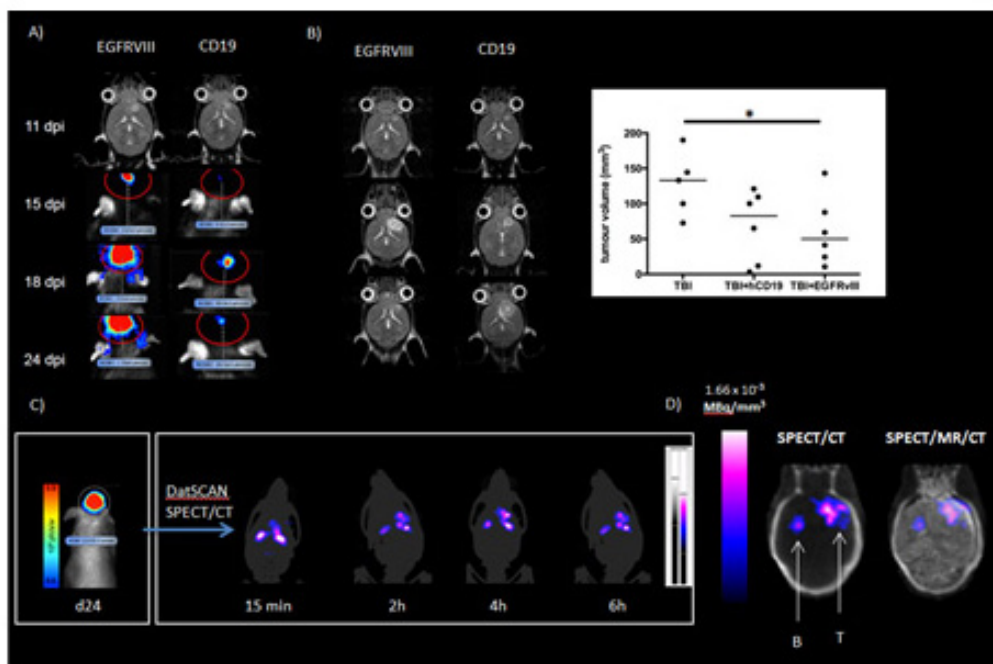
A) MRI of GL261 tumours pre-treatment at day 11, and BLI of subsequent CAR T cell uptake (EGFRvIII or Control CD19) at days 15, 18, and 24. B) MRI of GL261 tumour size pre-treated (top row) and post treated (EGFRvIII or Control CD19), and a graph of tumour volumes. C) BLI indicating hDAT (+) SupT1 cells in the brain, and uptake of DatSCAN by SPECT/CT over 6 hours showing signal the tumour and background basal ganglia. D) SPECT/CT co-registration with MRI data (B = basal ganglia, T = tumour).
